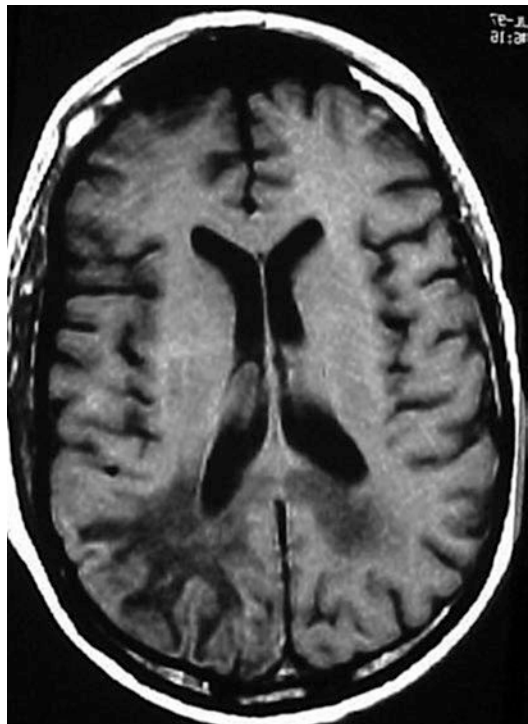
Progressive multifocal leukoencephalopathy. T1-weighted magnetic resonance imaging
